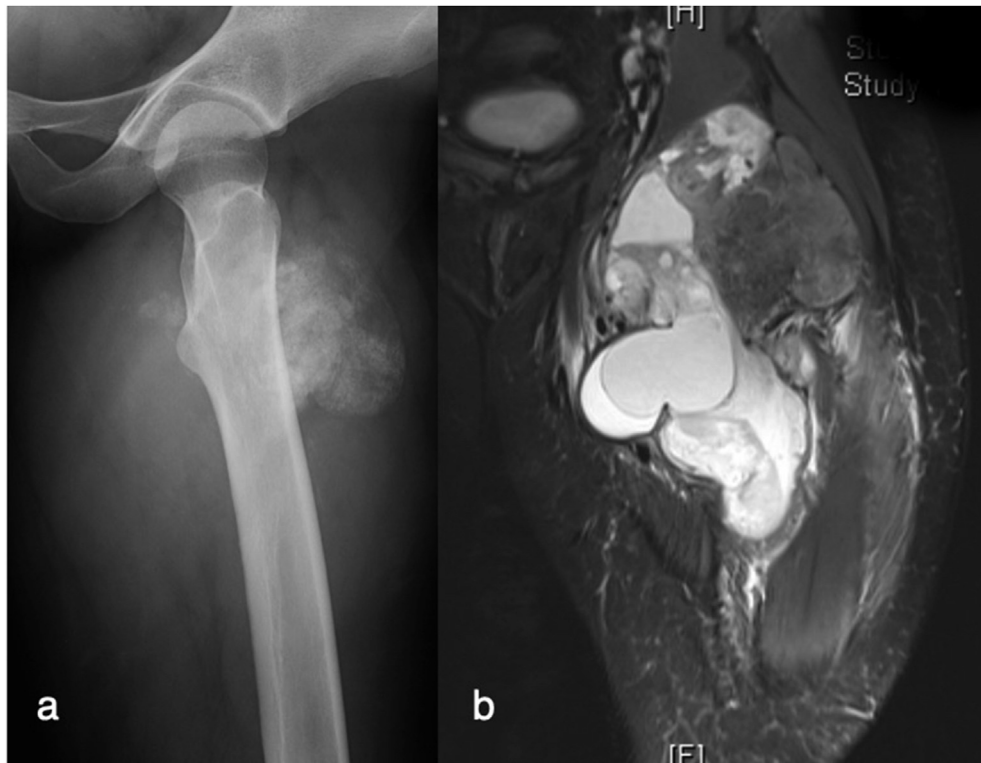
Synovial sarcoma. AP radiograph of the left proximal femur (a) demonstrates amorphous calcification partially overlying the left proximal femur without any evidence of periosteal reaction. A coronal fluid-sensitive fat-suppressed image (b) reveals a complex heterogenous mass which was subsequently proved to be a synovial sarcoma on biopsy.
